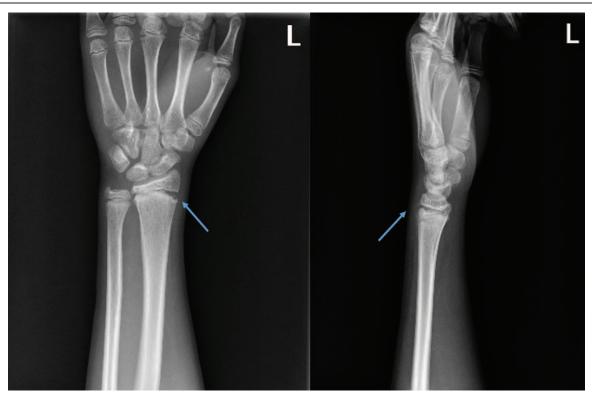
Anteroposterior and lateral radiographs showing the physeal fracture of the radius.
